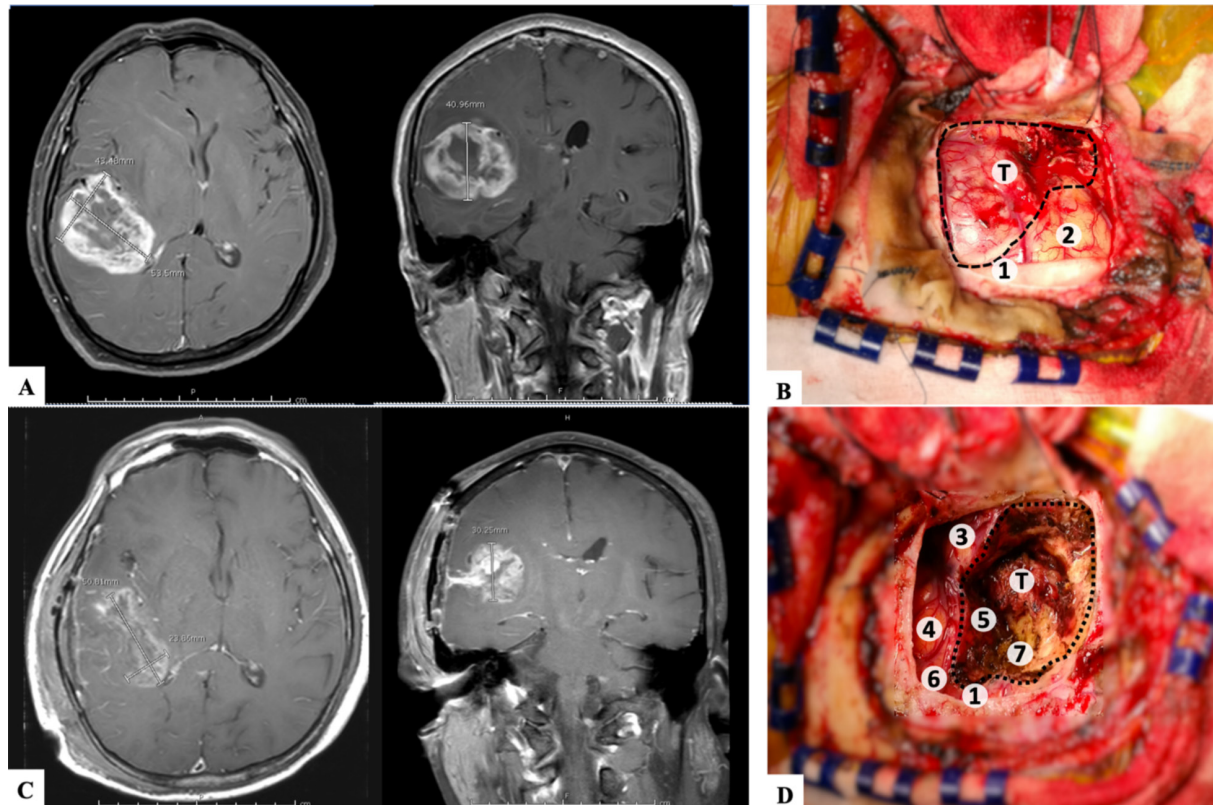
A Preoperative axial and coronal T1-weighted with gadolinium injected magnetic resonance imaging showing an enhancing tumor at right temporo-parietal lobe with calculated volume 47.6 milliliters. B Intraoperative finding before resection. Alphabet tag (T) and dash line showing the boundary of tumor, which defined by intraoperative ultrasound. The number of tags related to the eloquent cortex: Tag 1, the primary somatosensory cortex, eliciting left face and lip dysesthesia Tag 2, suspected the inferior parietal lobule which found negative stimulation. C Postoperative day 3, axial, and coronal T1-weighted with gadolinium injected magnetic resonance imaging showing an enhancing residual tumor, calculated volume 18.3 milliliters. D Intraoperative finding after resection, dot line showing the boundary of the tumor resection cavity. Alphabet tag (T) showing the remaining tumor. Tag 3, the superior temporal gyrus Tag 4 and 5, the primary motor cortex, eliciting left face and finger movement Tag 1 and 6, the primary somatosensory cortex and Tag 7, suspected subcortical thalamocortical fibers, eliciting left face and lip dysesthesia.
